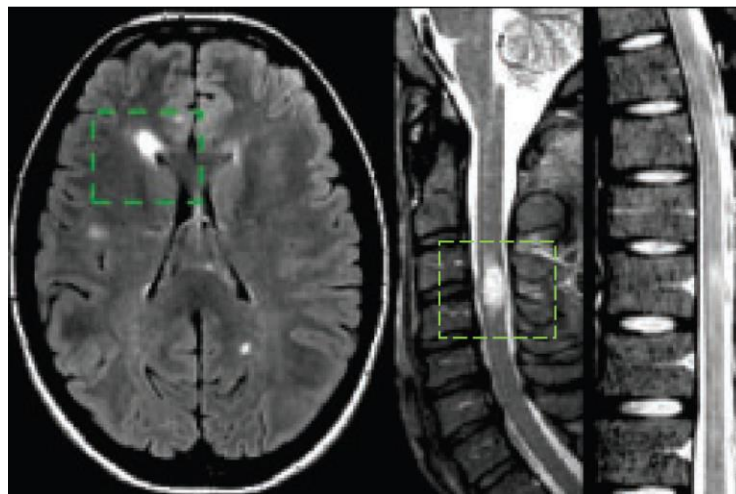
Multiple Sclerosis lesions appear on an MRI scan as either bright or dark spots and tend to have an oval or frame shape (Filippi et al., 2019).
